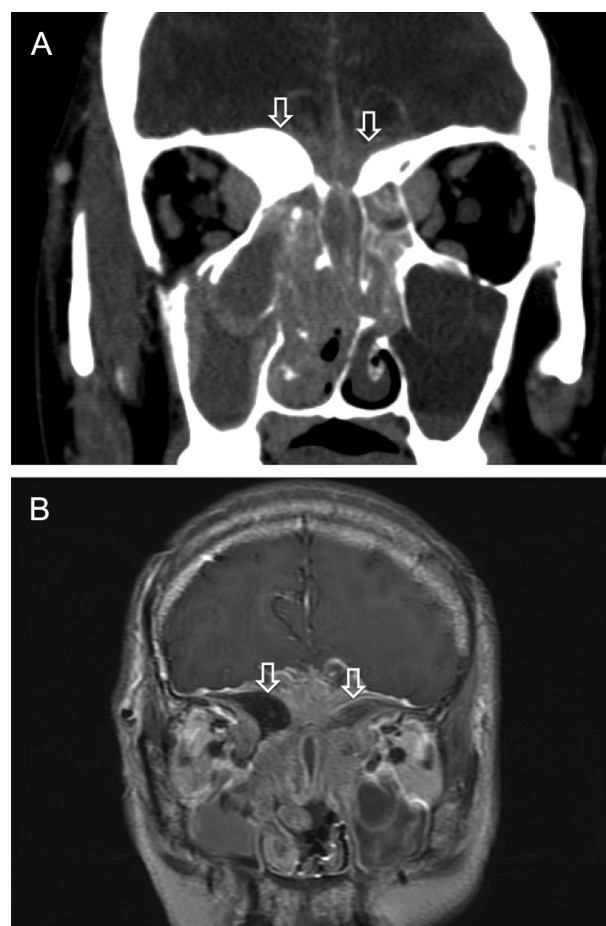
Preoperative coronal images of (A) the contrast brain computed tomography and (B) contrast-enhanced T1-weighted magnetic resonance imaging reveals an extensively enhanced soft tissue tumor involving the bilateral nasal and orbital cavities, ethmoid sinuses, the floor of the anterior cranial fossa, and the posterior part of the cribriform plate, with hyperostotic bones (arrows) at the anterior cranial fossa base.
